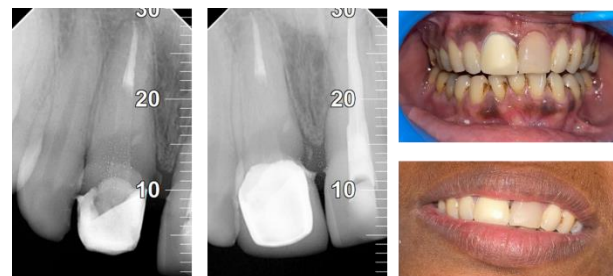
Core build up, Crown, Post-operative radiograph and clinical.
